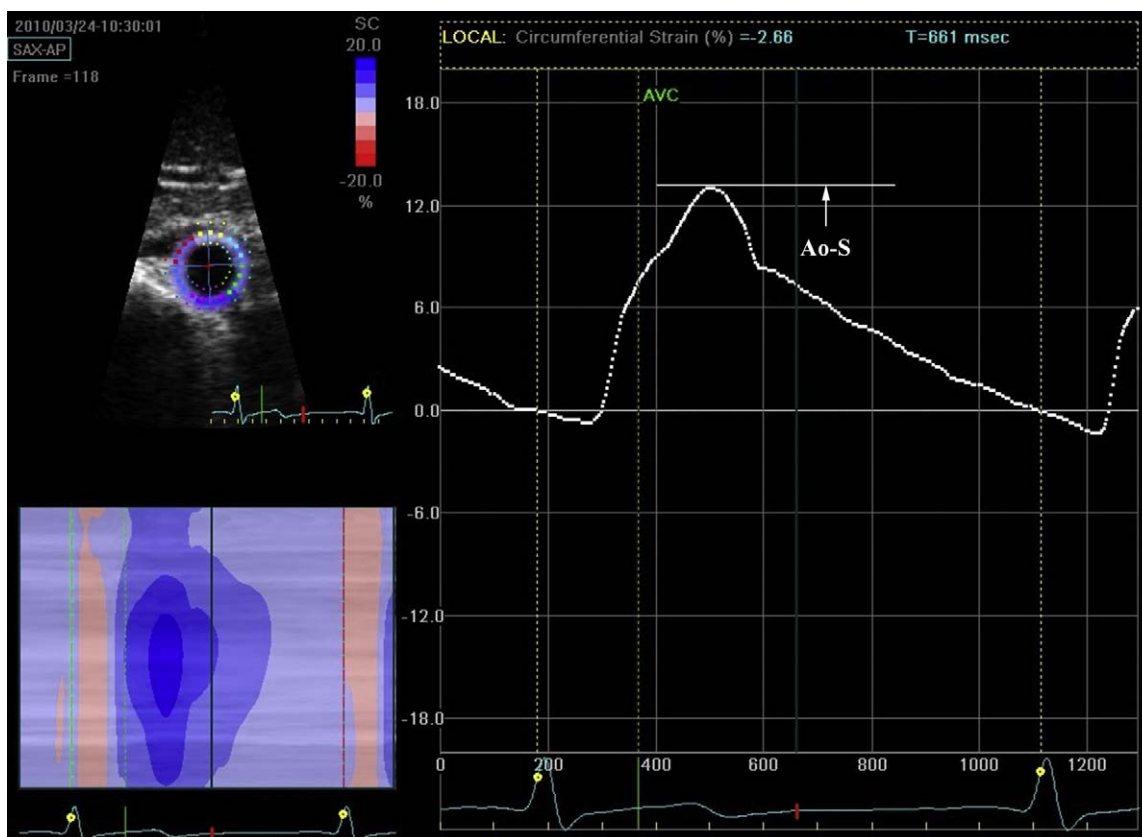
Measurement method of aortic circumferential strain by 2D strain echocardiography. Ao-S, peak strain determined by aortic circumferential strain curve.
